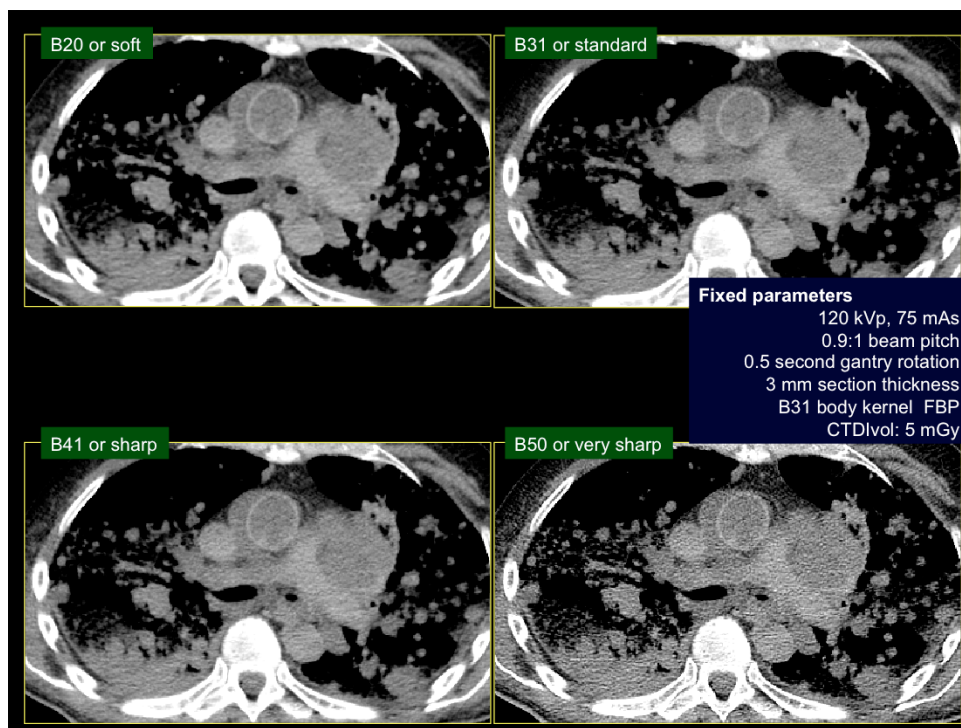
Transverse chest CT images in mediastinal windows at various kernels (B20 to B50). B20 im
